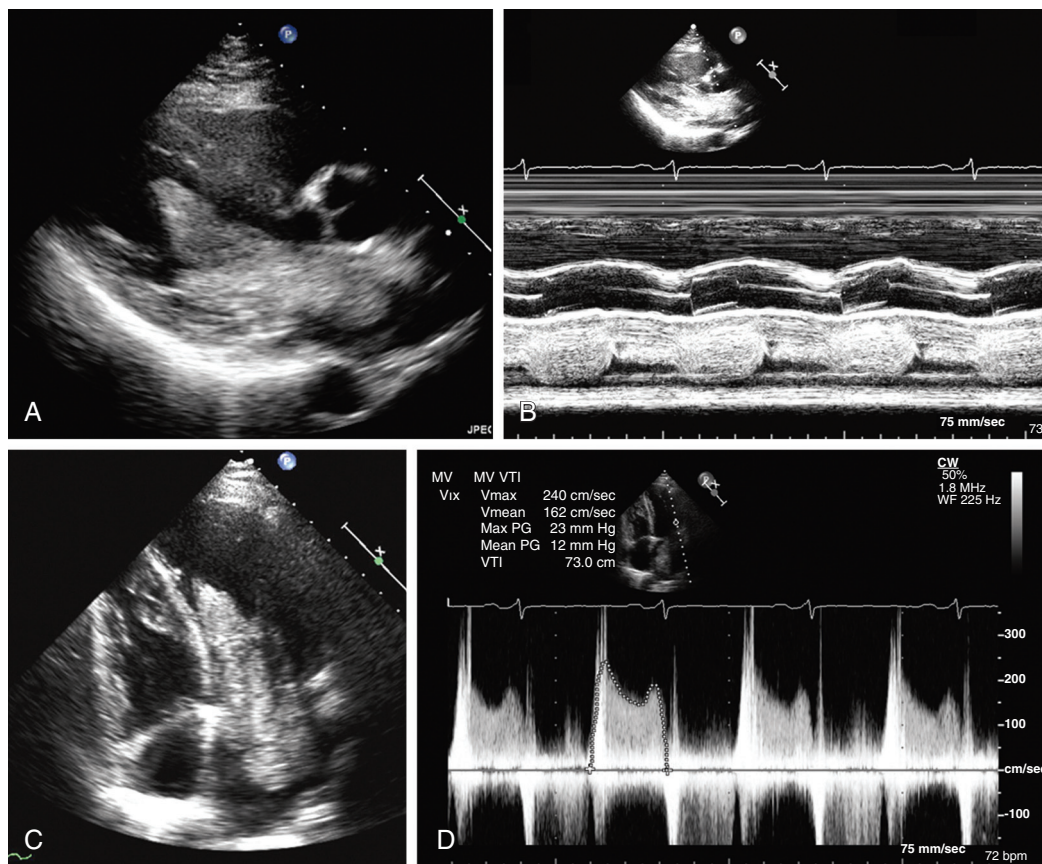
LA myxoma. A, Parasternal long-axis view. B, M-mode view showing the mass prolapsing into the left atrium in systole. C, Apical four-chamber view. D, Transmitral gradients (mitral stenosis) as shown by CW Doppler, with peak and mean gradients of 23 and 12 mm Hg. (Modified from Wu J: *Cardiac tumors and masses*. In Stergiopoulos K, Brown DL [eds]: *Evidence-Based Cardiology Consult*. Springer Science + Business Media, Inc., 2014.)
